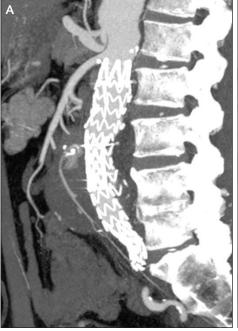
Pre CT (A). Post-CT after Onyx™ liquid embolic system (B).
